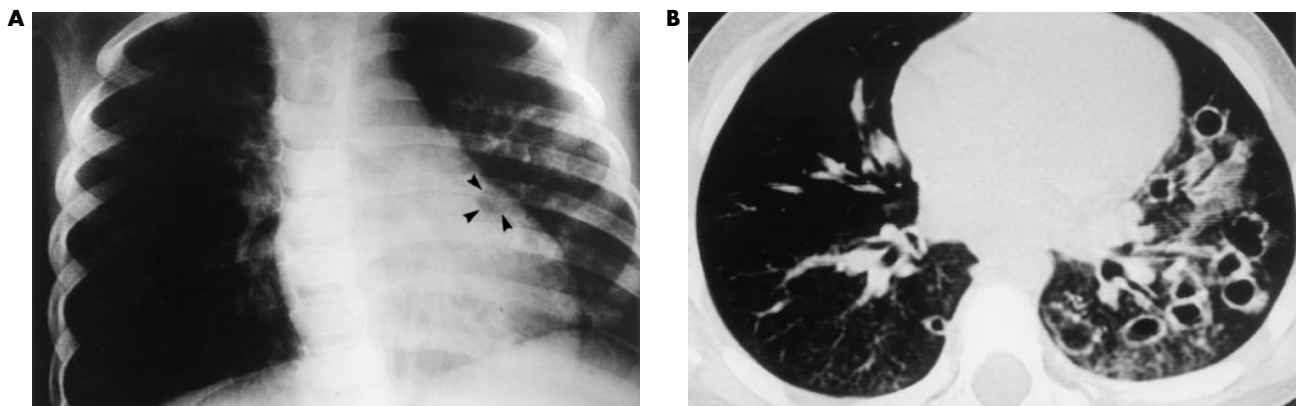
A, Chest radiograph and B, computed tomogram showing multiple cavitary pulmonary papillomas in a child with recurrent respiratory papillomatosis.
